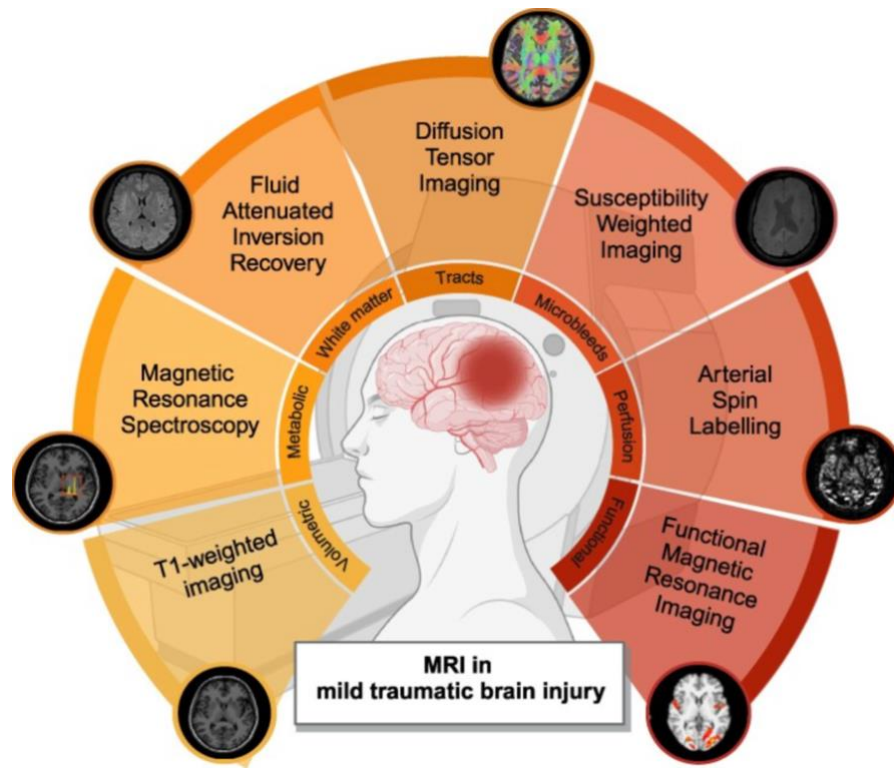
Magnetic resonance imaging (MRI) structural and functional modalities and uses (Sassani et al., 2025)
